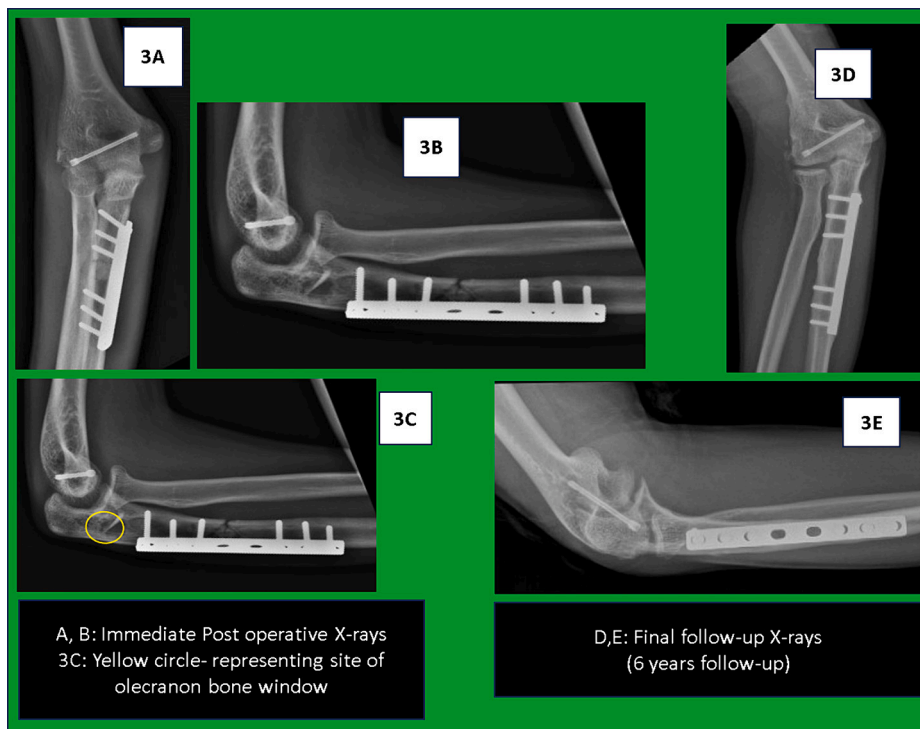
Postoperative X-rays (A–C: Immediate postoperative x-rays showing fixation of proximal ulna with dynamic compression plate and autologous olecranon cancellous bone graft and Herbert screw fixation for capitellum, D, E: 6 years follow-up X-rays, yellow circle-representing site of olecranon bone graft window).
